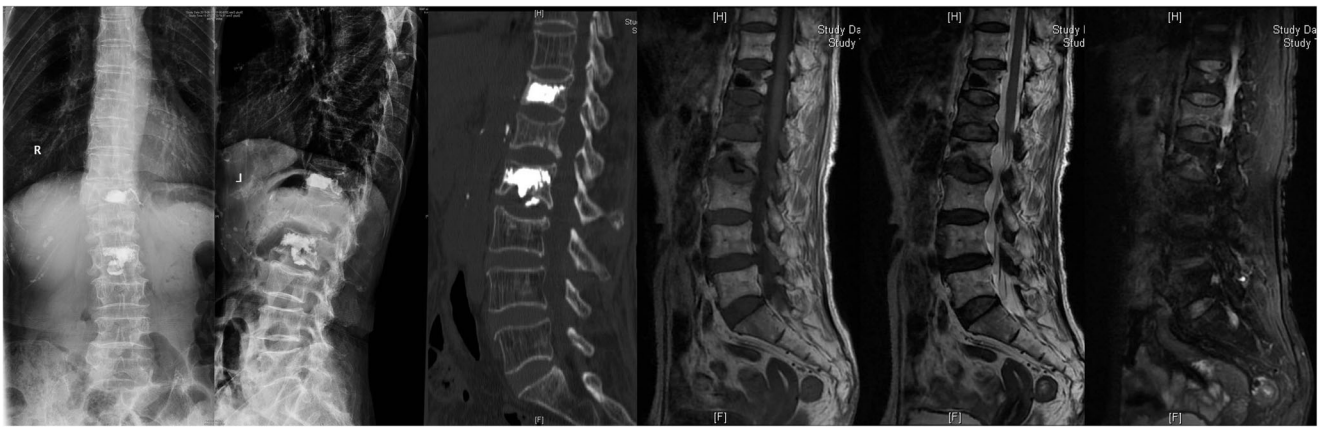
Three months later, patient A complained of severe back pain again without obvious incentive. Spine X-ray and MRI showed L1 fracture
